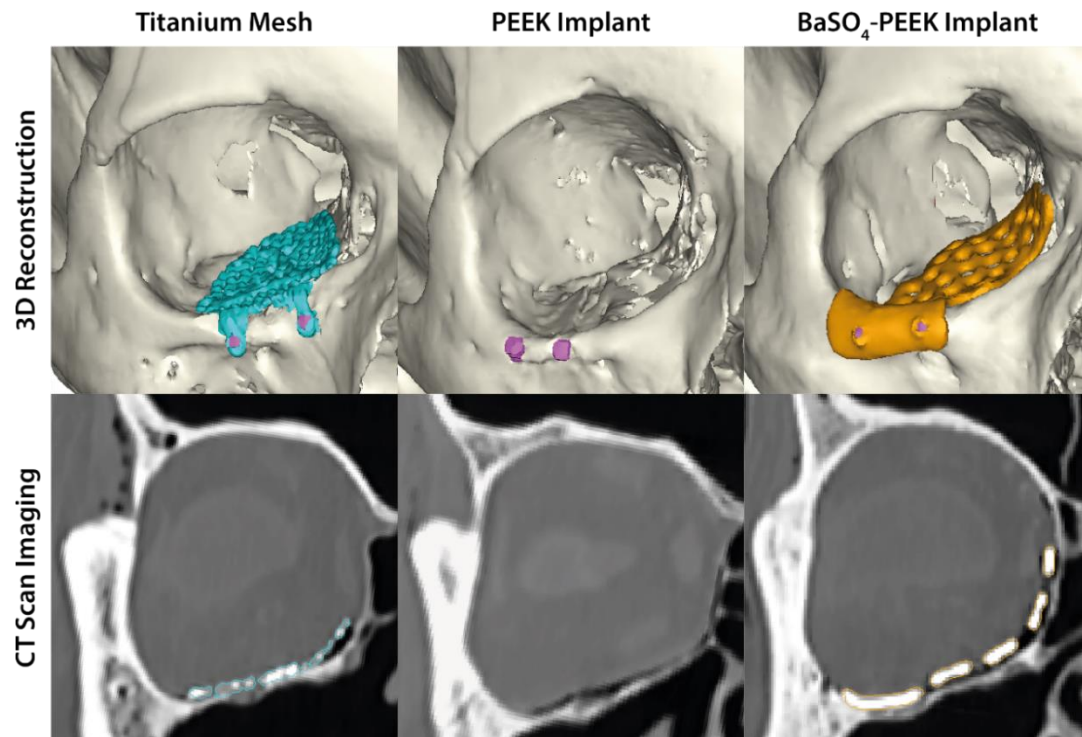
Radiographic visibility of fused filament fabrication (FFF) 3D-printed orbital implant materials on postoperative computed tomography (CT) imaging. Top row: Three-dimensional (3D) reconstructions showing titanium mesh (left), FFF polyetheretherketone (PEEK) (middle), and FFF BaSO₄-PEEK (right) orbital implants in situ with fixation screws. Bottom row: Corresponding coronal CT slices demonstrating titanium mesh with metal artefacts (left), radiolucent unfilled PEEK implant (middle, not visible), and radiopaque BaSO₄-PEEK implant (right) with clear margin delineation and minimal artefacts.
